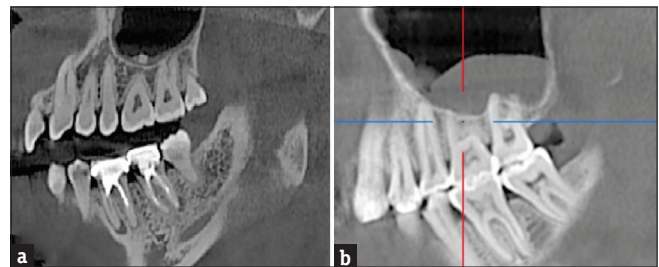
(a) A multiplanar reformatted sagittal cone beam computed tomography image of an antrolith within the maxillary sinus. (b) A multiplanar reformatted sagittal cone beam computed tomography image of a mucous retention cyst within the maxillary sinus
